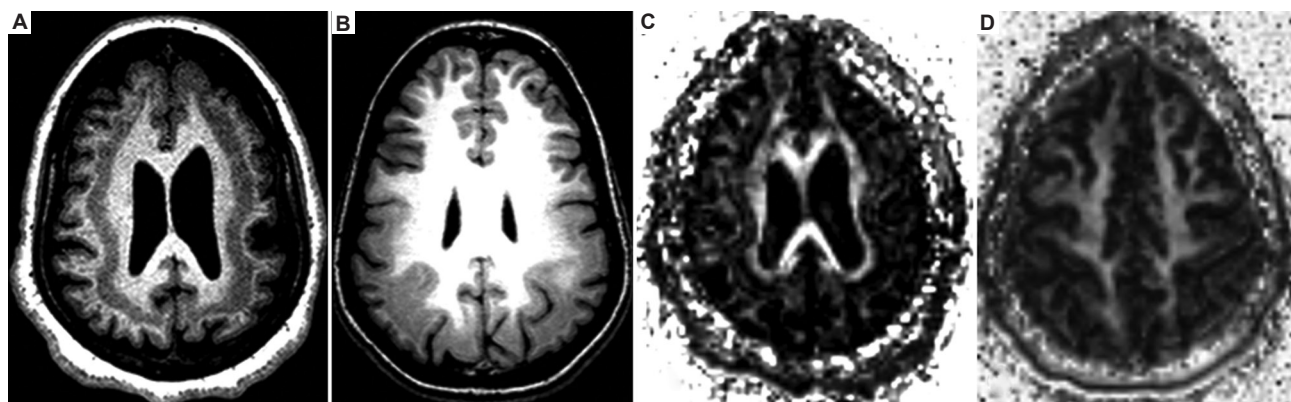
Magnetic resonance imaging. T1-weighted images (A and B) and FA maps (C and D). Patient 1 showed a band heterotopia extending throughout both hemispheres, whereas in patient 2, the heterotopia was confined to the parieto-occipital region. In both cases, FA maps showed increased signal within the bands, which appeared to be more structured in patient 2, particularly on the right (D). A subcortical area free from gray matter was clearly visible in patient 1, but it could be identified as a small strip of white matter in patient 2. The overlying cortex appeared pachygyric.
